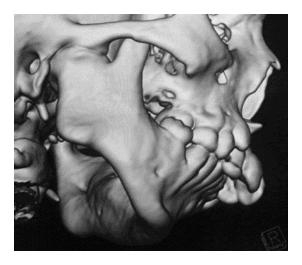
3-D CT scan showing ankylotic mass.
